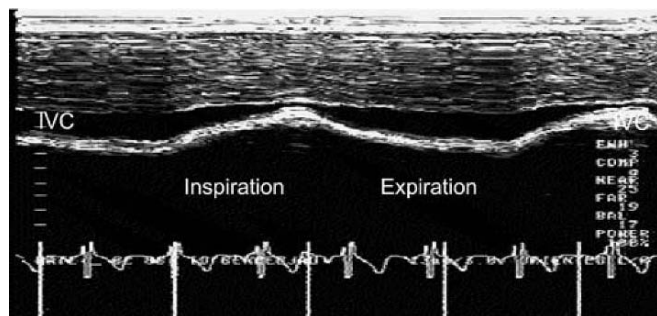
An example of M mode echocardiography of the inferior vena cava (IVC) in spontaneously breathing asthmatic patients. Note the short duration of inspiration, accompanied by a collapse of the vessel, and the increased duration of the expiration (compare Fig. 4, above)
